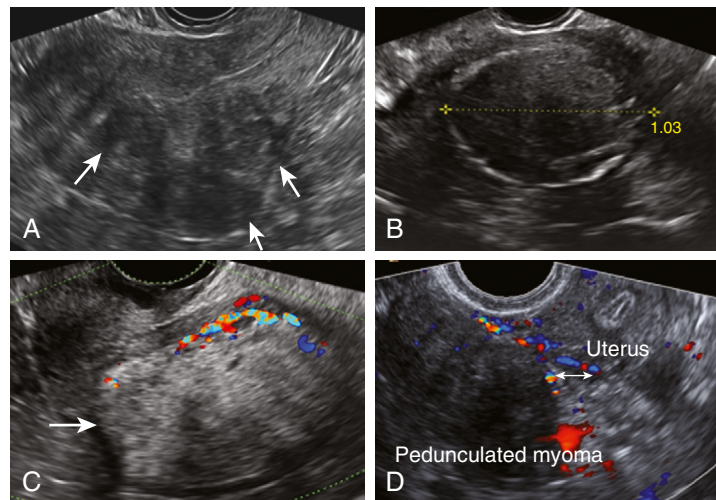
Uterine fibroids appear as solid, well-defined round lesions within the uterine corpus. (A) Longitudinal view of the uterus with three hypoechoic myomas with acoustic shadowing in the posterior wall (arrows). (B) Transverse view of the uterus with a myoma with a calcified echogenic ring. (C) Transvaginal sonography retroverted uterus with a fundal myoma with lipomatous degeneration (arrow). (D) A pedunculated myoma with color Doppler flow demonstrating flow contiguous with the uterus (double-headed arrow).
